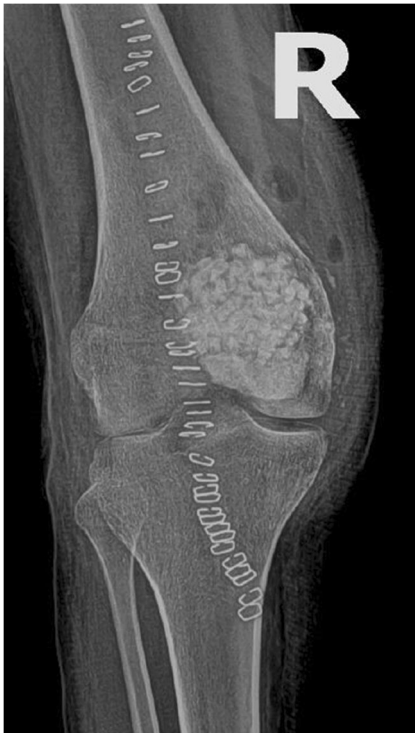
AP radiograph of the right knee immediately post curetting and packing with bone graft substitute
